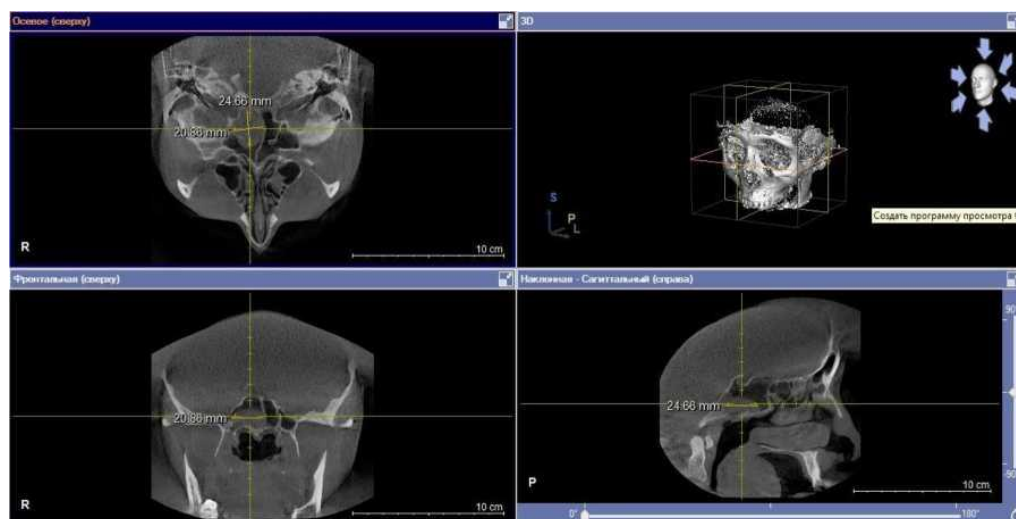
Computed tomography of a patient with a cyst of the right sphenoid sinus
